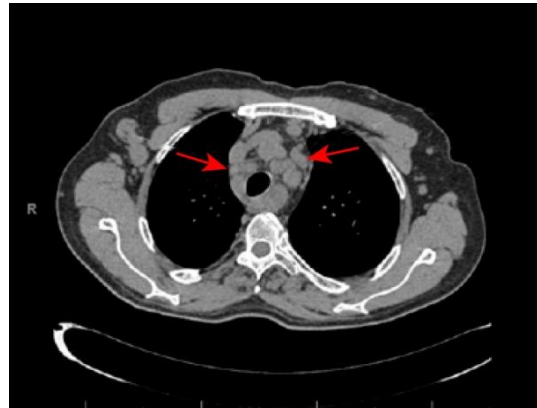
Axial computed tomography scan showing lymphadenopathy at the mediastinal area (red arrows) with clear lung parenchyma. Reproduced from: [11] under the Creative Commons Attribution License.
